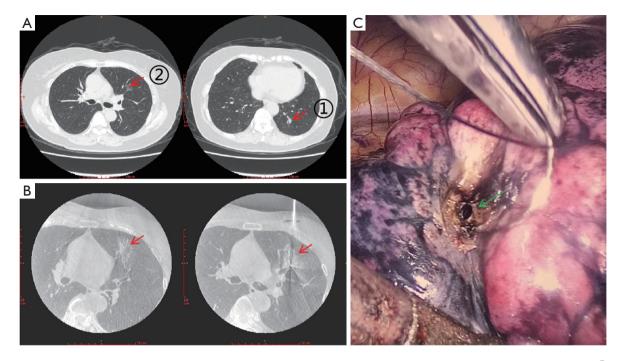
Images of chest CT scanning and surgery in case 2. (A) Pre-surgery scanning of nodule 1 and 2 (red arrows, marked as ① and ②). Nodule 1 is a mixed GGN and located in the anterior segment of left upper lobe with biggest diameter of 1.5 cm. Nodule 2 is a mixed GGN and located in the posterior basal segment of left lower lobe with biggest diameter of 1.1 cm. Nodule 2 was treated by lobectomy of left lower lobe. (B) Images of intraoperative localization of nodule 1 under real-time guide by a C-arm X-ray. This nodule was treated by microwave ablation with intraoperative localization under real-time guide of a C-arm X-ray machine. Red arrows show the position of the ablation needle tip. (C) An ablation-induced bronchopleural fistula (green arrow) was identified during the thoracoscopic procedure and was repaired with sutures, and favorable postoperative recovery was obtained. CT, computed tomography; GGN, ground glass nodule.
